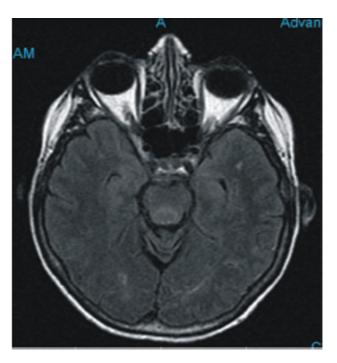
MRI Brain done 2 weeks later: T2 image shows complete resolution of white matter changes seen in Figure 1.
